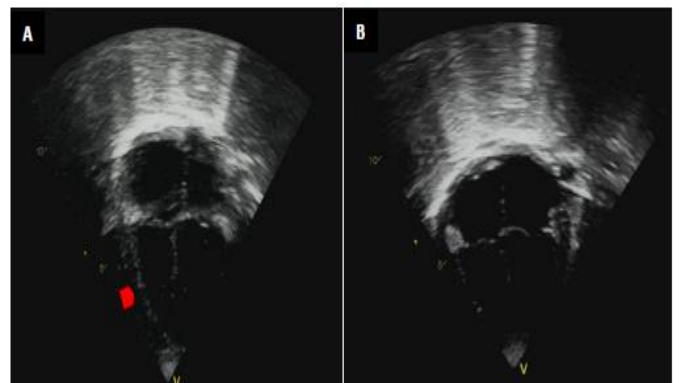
A. Patient's echocardiography on the 3rd day after pericardiostomy showing small pericardial effusion (arrow) with no chamber collapse, EF is 68%. B. Repeat 2D-echo 25 days post-pericardiostomy demonstrating resolution of pericardial effusion with no evidence of constriction.
